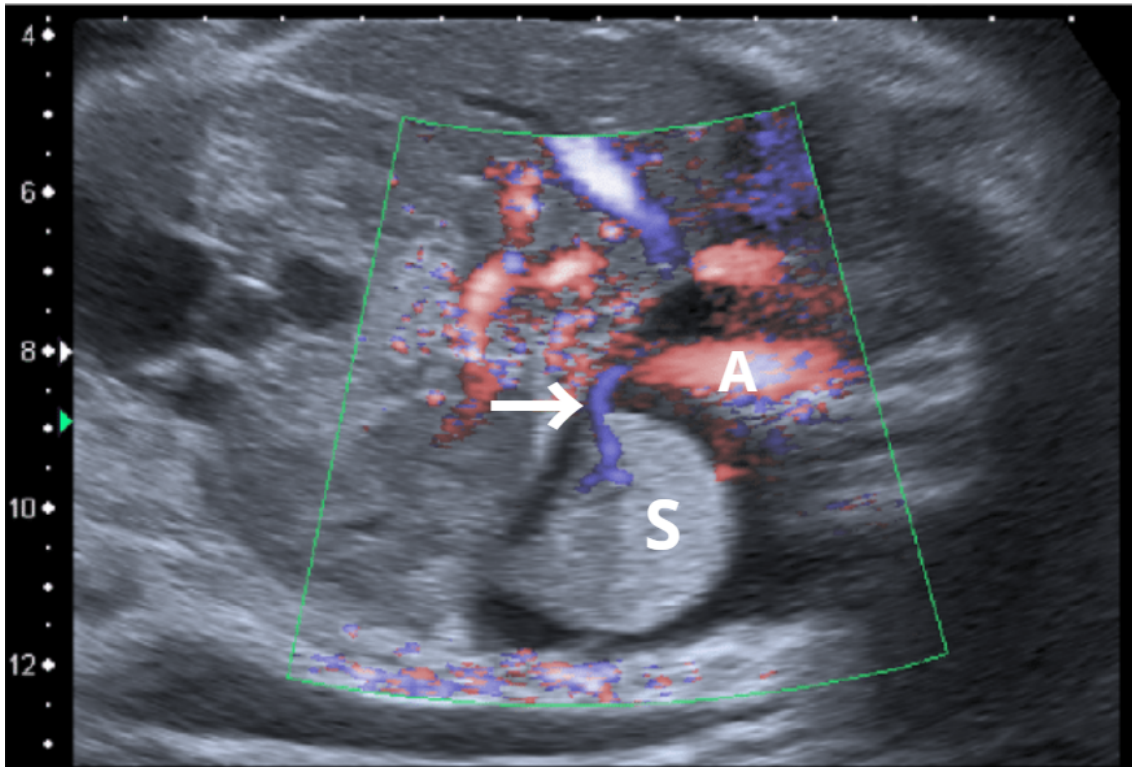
Fetal ultrasound with Doppler, week 31+6. Lung sequestration (S), the white arrow pointing to the feeding vessel branching from the aorta (A).
